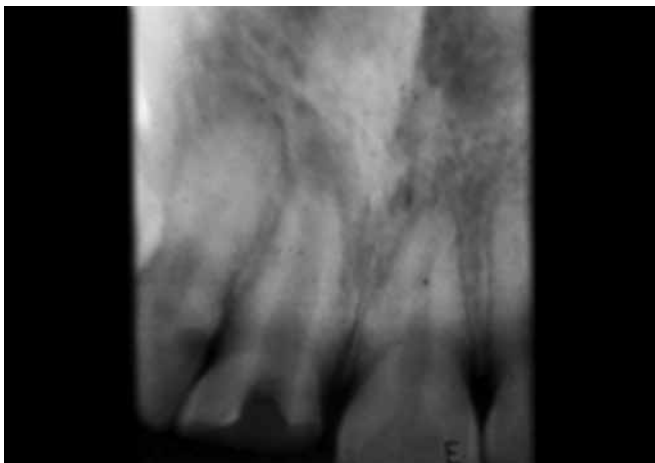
Preoperative radiograph showing open apex (case 3)
